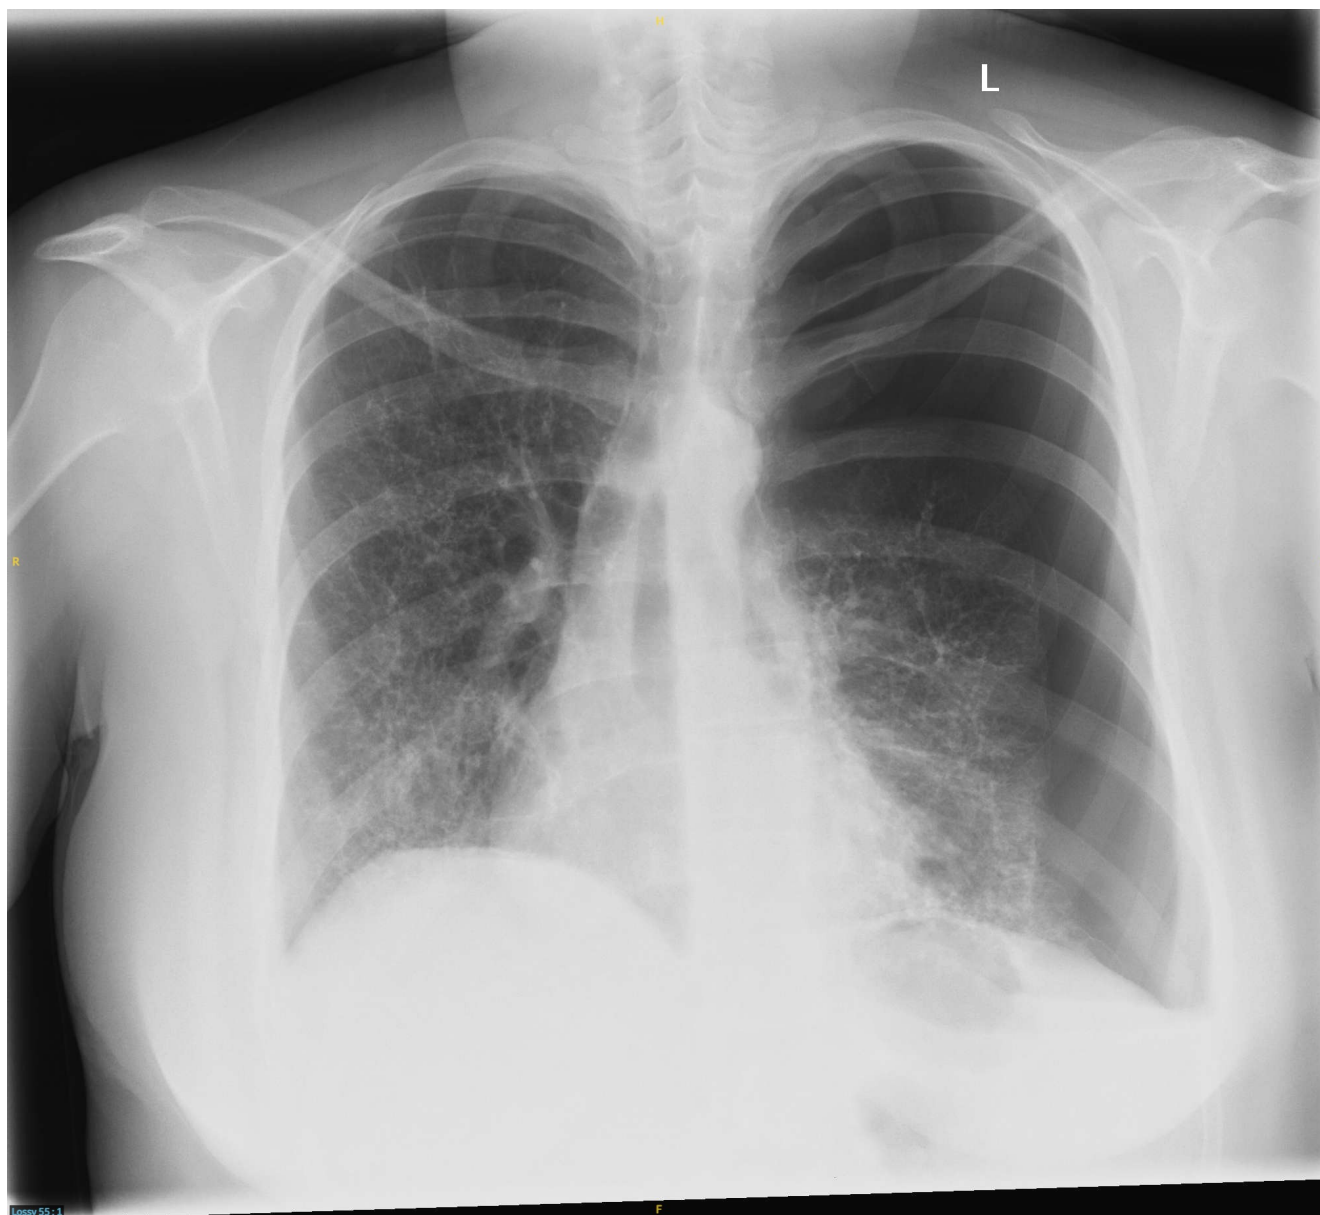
A posteroanterior chest X-ray showing a large left-sided pneumothorax with evidence of mediastinal shift. L, left.
